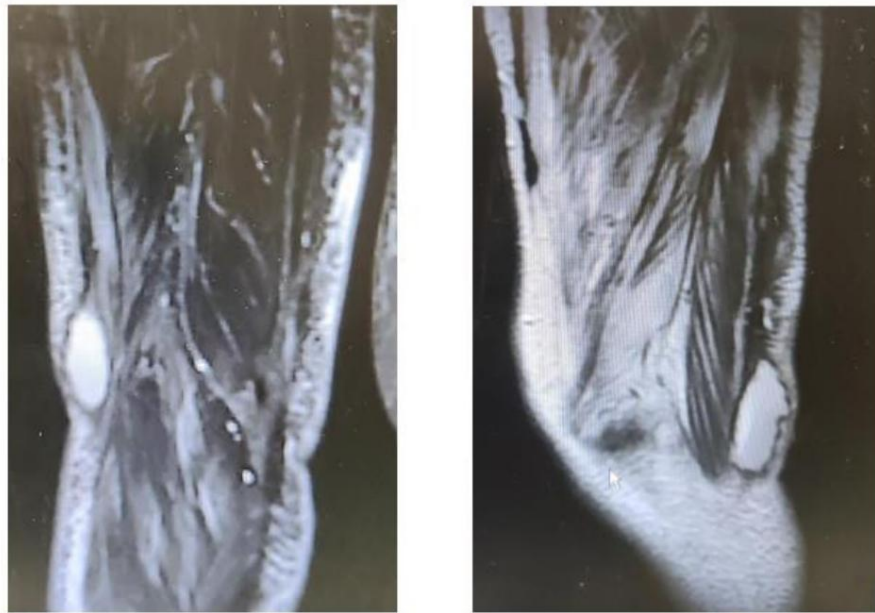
Last MRI control of a hydatid cyst in the thigh.
